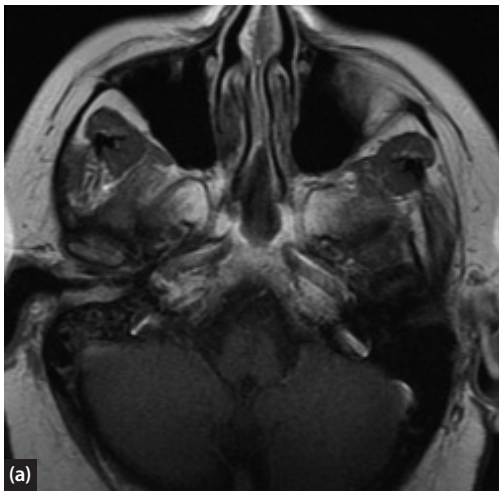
MR imaging with gadolinium enhancement showing early stage SCC within the right ear canal (a) MR axial and (b) MR coronal. CT imaging reveals that the same disease does not invade the middle ear cavity (c) CT axial and (d) CT coronal. Images courtesy of Colchester Hospital University NHS Foundation Trust.
